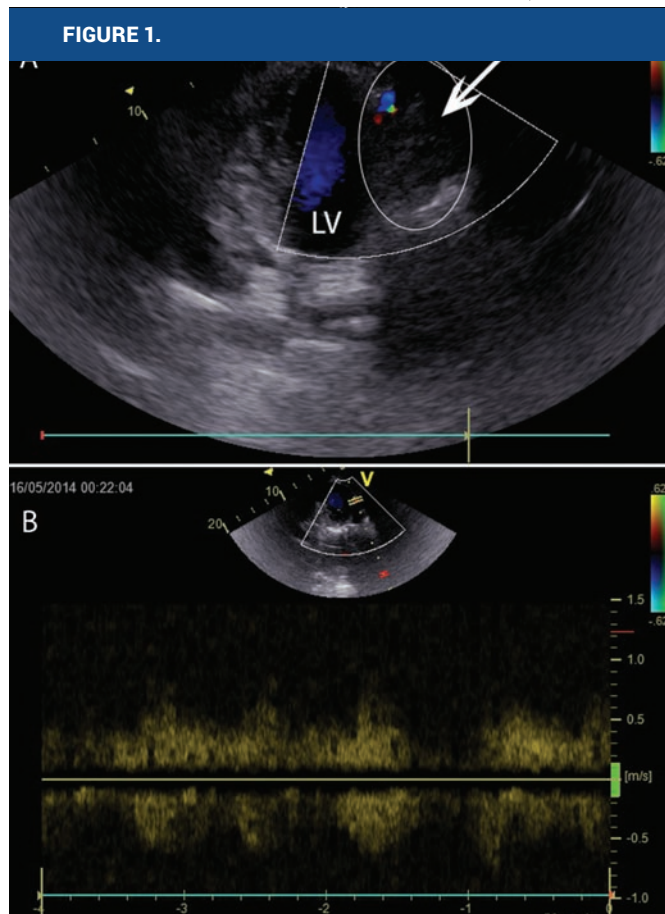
Transthoracic echocardiography image showing paracardial tumour mass (within ellipse, marked by arrow) adjacent to left ventricle (LV) (Panel A). The tumor was well vascularized, pulsed Doppler flow-line spectrum indicating low resistance flow (Panel B).
